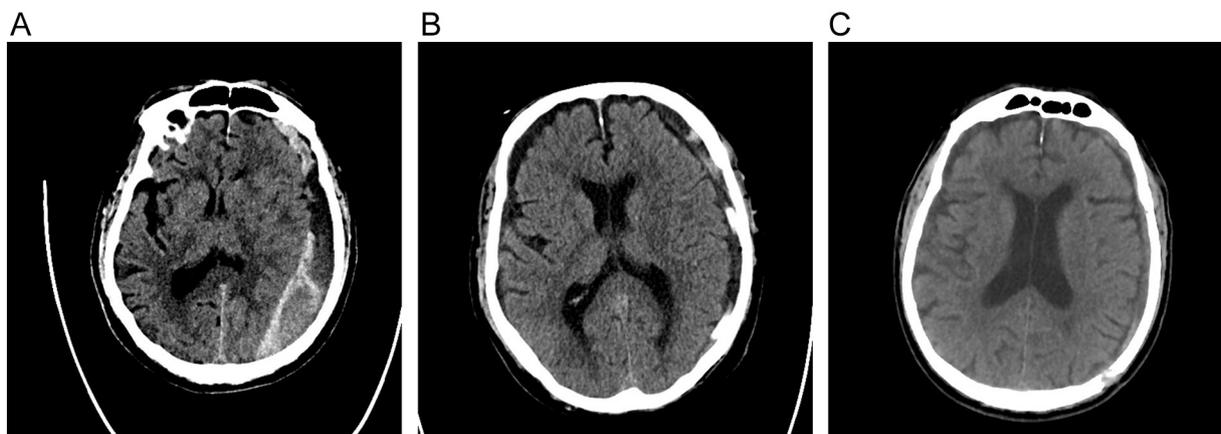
Imaging from case 4. A: Pre-operative axial CT image demonstrating mixed attenuation left SDH with mass effect on the left hemisphere and midline shift. B: Post-operative CT demonstrating SDD with decreased size of left side SDH with decreased mass effect and shift. There is mild pneumocephalus. C: 1-month follow-up CT demonstrating small residual SDH.
